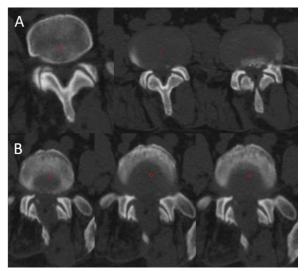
Preoperative (A) and postoperative (B) CT scans showing bone resection for unilateral access for bilateral recess stenosis
